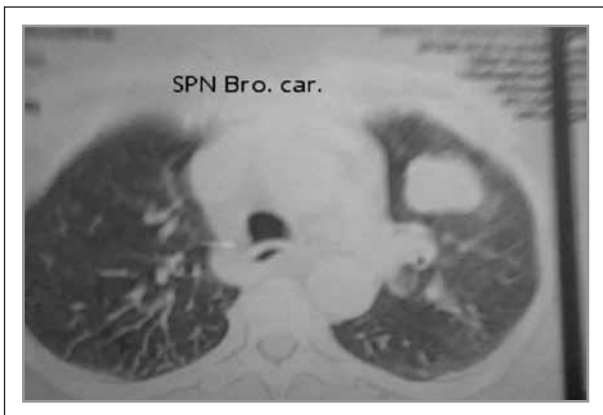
Photo was showing CT chest with NSCLC stage 1
